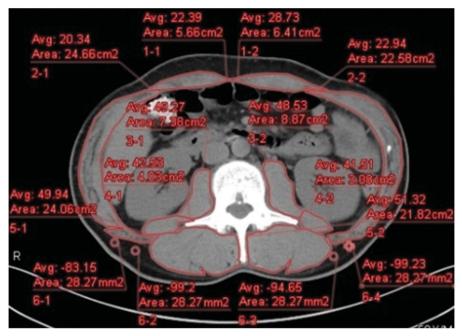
Evaluation of skeletal muscle in a transverse CT image at the third lumbar vertebra (L3).
